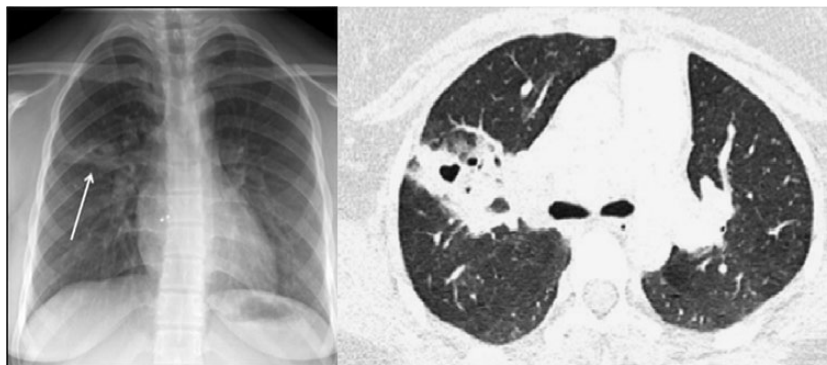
Chest radiograph (left) and axial computerized tomography (right) images demonstrating contiguous cavities with characteristic “bunch of grapes” appearance (arrow).
